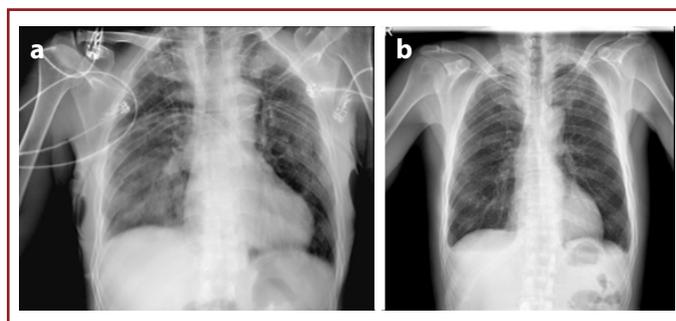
(a) X-ray taken after tube thoracostomy was inserted. (b) X-ray taken after 17 days discharged. Multiple rib fractures, subcutaneous emphysema, multiple lung contusions, particularly on the right.
